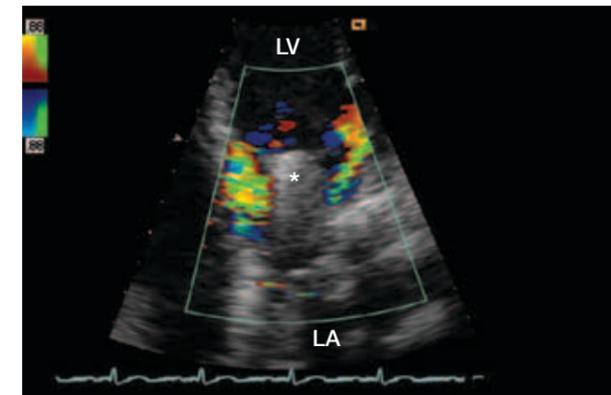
This zoomed apical 4-chamber view was recorded from a patient with a Starr-Edwards mitral valve replacement. Observe that transprosthetic flow diverges laterally around ball occluder (*).
